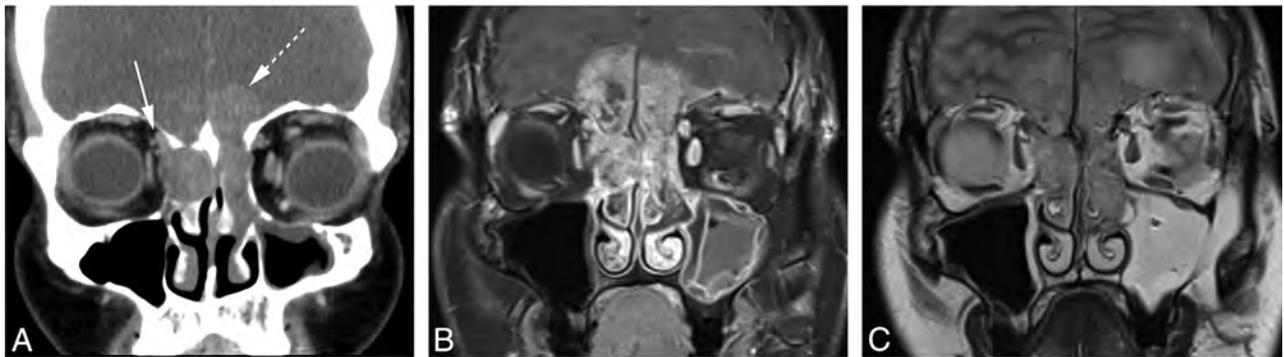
Patient 1. A, Coronal enhanced CT image shows moderately enhancing tumor in the nasoethmoidal region eroding the cribriform plate and ethmoid roof, with intracranial extension more conspicuous on the left (*dashed arrow*). There is also erosion through the right lamina papyracea with contact to the right superior oblique muscle (*solid arrow*). Bone changes in this case were deemed primarily erosive rather than expansile. B, Coronal enhanced and fat-suppressed T1WI shows avid heterogeneous enhancement in the transcranial mass. C, Coronal T2WI shows mild T2 hyperintensity of the transcranial mass compared with the cerebral cortex. Though there is signal abnormality in the left frontal lobe, no intradural disease was identified during surgical resection.
